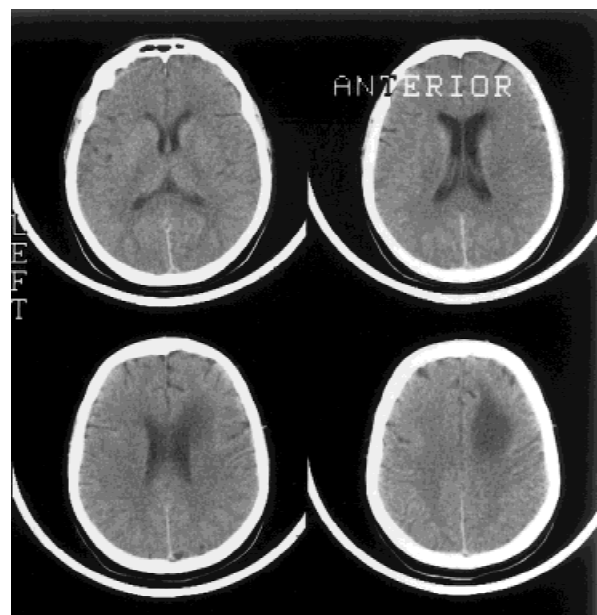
Postoperative CT scan with reversed sides compared with Figure 1 showing a mainly right-sided sharply demarcated frontoparietal hypodensity at the site of tumor resection. The hypodensity may be partly related to residual peritumoral edema or disturbed venous drainage.
